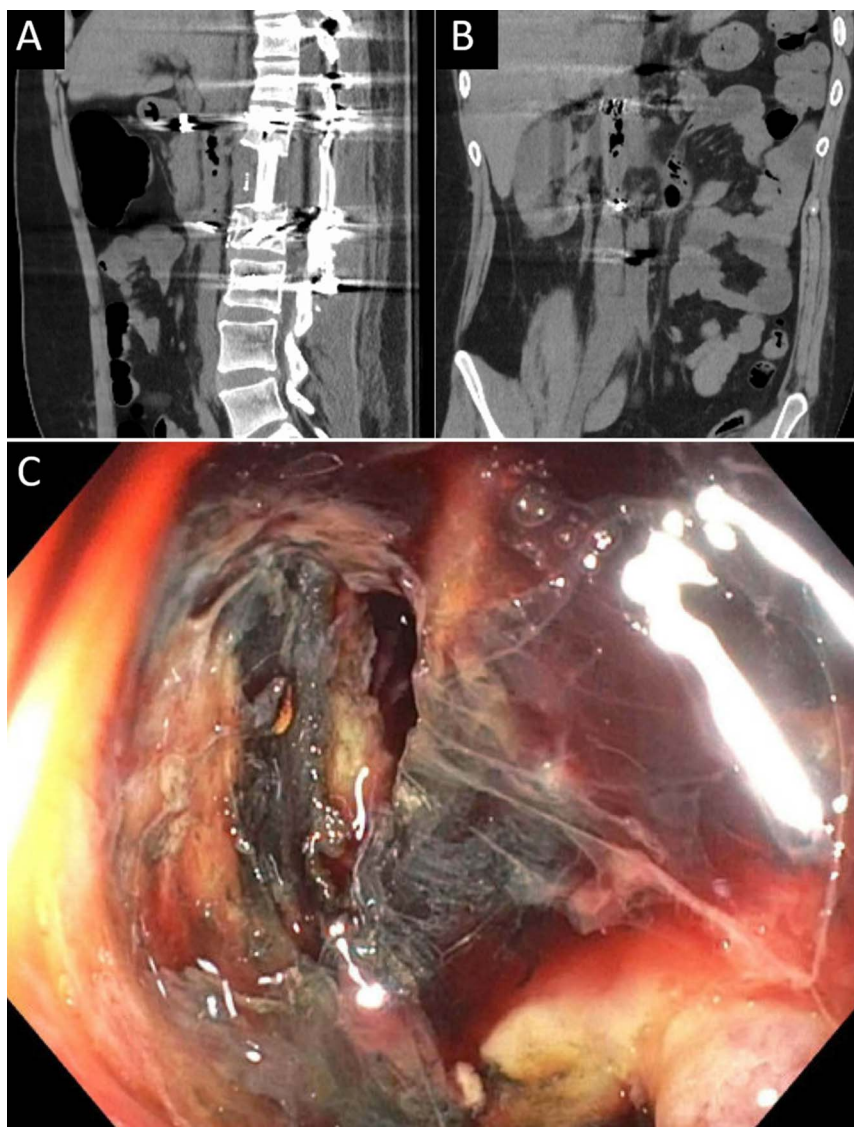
(A and B) Computed tomography imaging demonstrates multiple foci of gas within the inferior vena cava extending 6.8 cm craniocaudally from the level of the third portion of the duodenum to the level of gastroduodenal artery embolization consistent with duodenocaval fistula in sagittal (A) and coronal (B) views. (C) Endoscopic view of Forrest IIb ulcer with a suspected contained perforated ulcer base located at the junction of the second and third portions of the duodenum.
